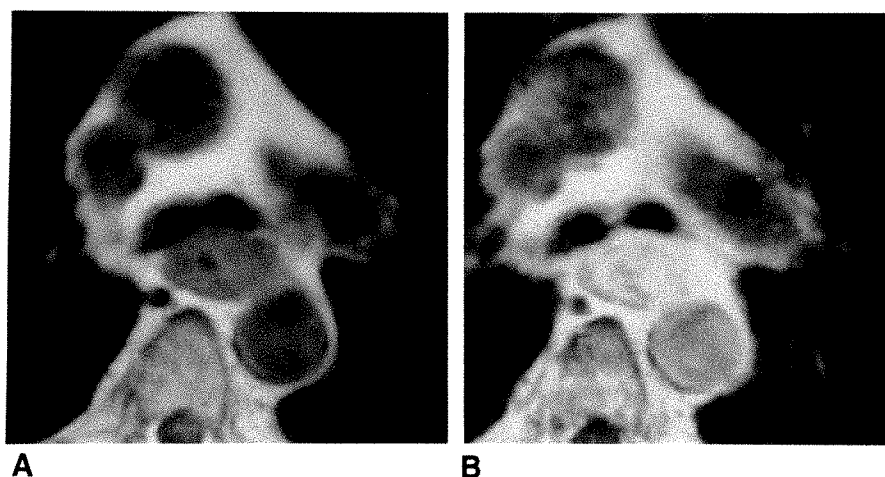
T1-weighted (SE 500/15) MR images of esophageal carcinoma obtained at 1.5 T before (A) and after (B) administration of gadopentetate dimeglumine. Note intense enhancement of tumor obscuring its border with adjoining fat.
